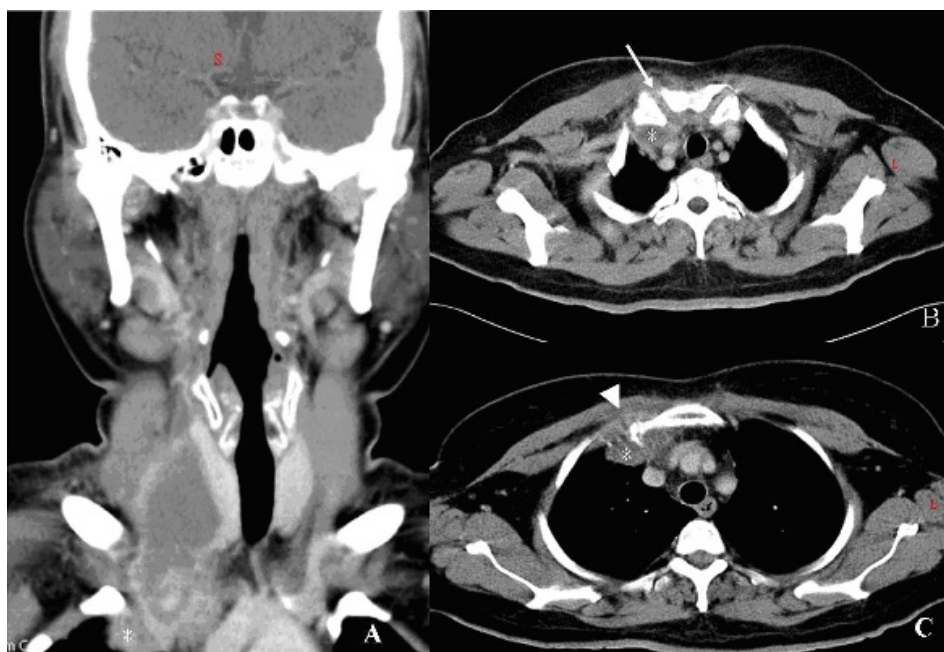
(A) The coronal computed tomography (CT) of the neck revealed a thyroid abscess, measuring 35 × 29 × 71 mm in size, with local phlegmon formation and extension to superior-anterior mediastinum (asterisk). (1B and C) The axial chest CT showed concomitant sternoclavicular joint infection with intra-articular joint involvement (arrow), mediastinitis (asterisk), and chest wall abscess (arrowhead).
